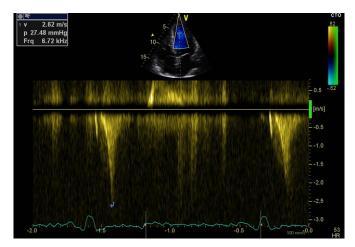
Continuous Doppler with demonstration of a transventricular gradient
